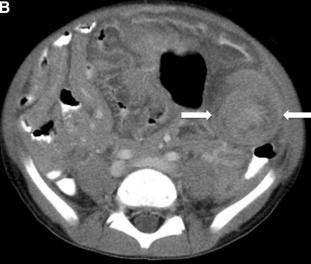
Coronal CT image with intravenous and oral contrast (A) shows multiple large, solid, and confluent soft tissue masses (asterisk) in the abdomen with mass effect on the adjacent vascular structures and abdominal viscera. Axial CT
